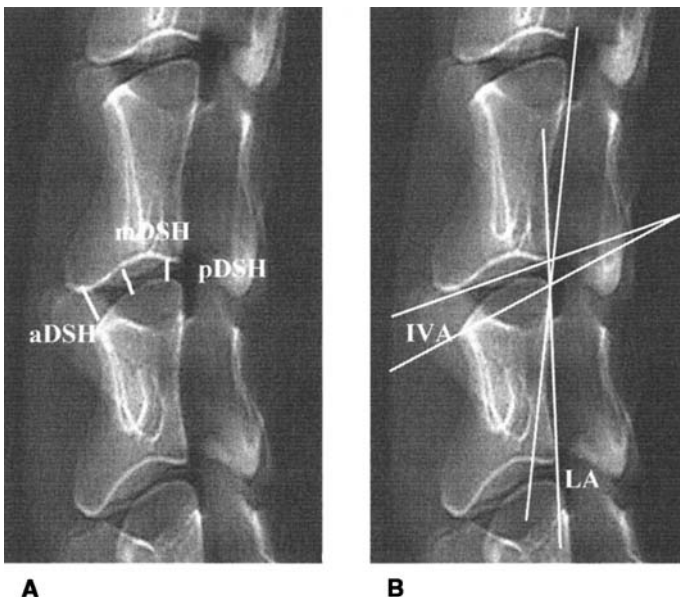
Radiographic measurements of (A) anterior disc space height (aDSH), posterior disc space height (pDSH), middle disc space height (mDSH), (B) intervertebral angle (IVA) and lordosis angle (LA).
